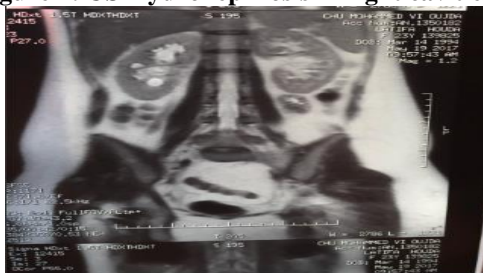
Uro MRI showing right hydronephrosis secondary to compression by pregnancy fetal head
